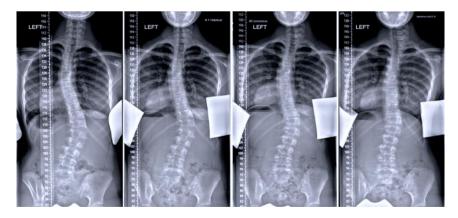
This fourteen-year-old patient, never braced, participated in the first Schroth Best Practice Program in the U.S. in July, 2008. Initial Cobb angles: (Left) 6/2008 at 26° left thoracic (T5-T10) and right thoracolumbar at 41° (T10-L3). Left Center (LC), Right Center (RC) and Right (R) x-ray images taken on 1/2009. (LC) 22°/37°, (RC) elongation at 21°/30°, and (R) with side-shift (translation) and elongation 18°/22°. 7/2008 ATR°: 7° thoracic/13° thoracolumbar. Five years later, 2/2014 ATR°: 4° thoracic/9° thoracolumbar. (X-ray with permission from Dr. Marc Moramarco, Scoliosis 3DCTM, Woburn, MA).
